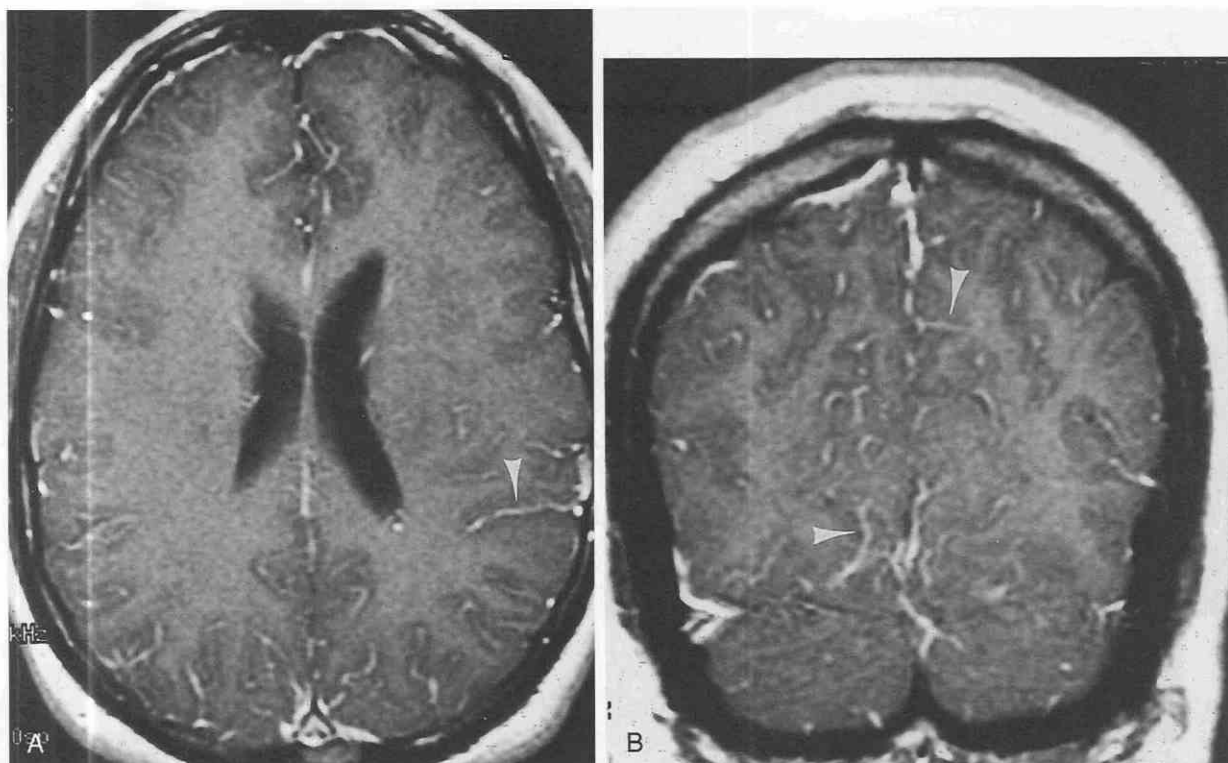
Aseptic meningitis. *A* and *B*, Thin, linear pia/subarachnoid space enhancement (*arrowheads*) is seen in a patient with headache and no organism growth on cerebrospinal fluid culture on axial and coronal enhanced T1-weighted images.
